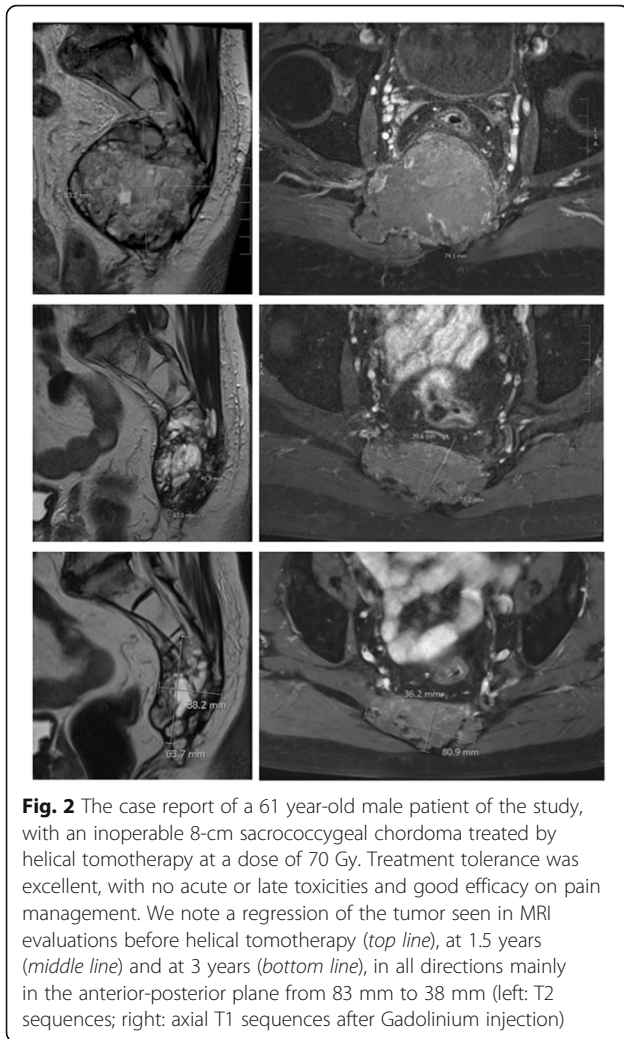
The case report of a 61 year-old male patient of the study, with an inoperable 8-cm sacrococcygeal chordoma treated by helical tomotherapy at a dose of 70 Gy. Treatment tolerance was excellent, with no acute or late toxicities and good efficacy on pain management. We note a regression of the tumor seen in MRI evaluations before helical tomotherapy (*top line*), at 1.5 years (*middle line*) and at 3 years (*bottom line*), in all directions mainly in the anterior-posterior plane from 83 mm to 38 mm (left: T2 sequences; right: axial T1 sequences after Gadolinium injection)
